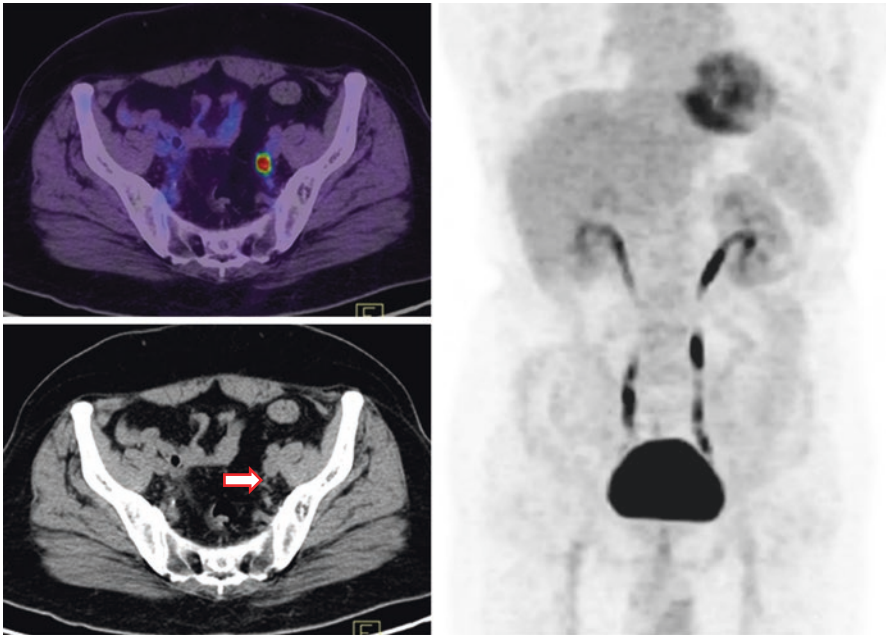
Ureteric pooling of tracer mimicking FDG avid lymph node in fused PET/CT images. Review of CT images confirms the absence of lymph node (*red arrow*), and review of MIP images reveals the characteristic pattern of urinary activity in ureter on both sides
